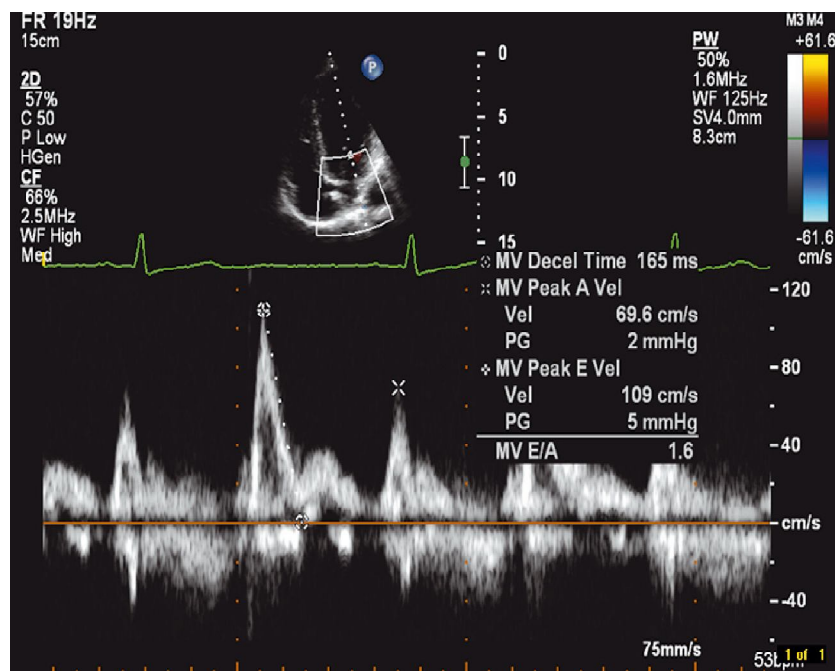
Pulsed-wave (PW) Doppler of mitral valve (MV) inflow(Houghton, 2013).
